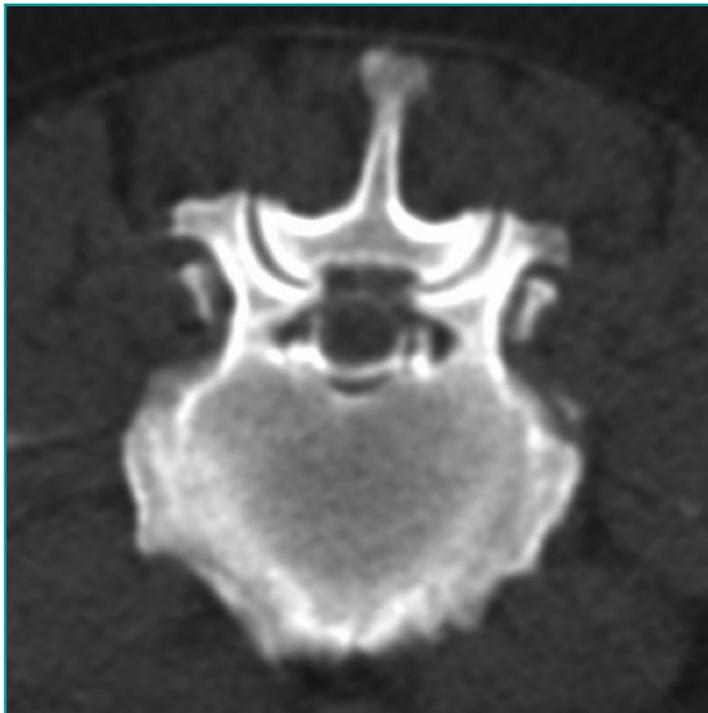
Transverse myelo-CT scan at the intervertebral space L4-L5; extensive spondylosis present throughout the spine.
